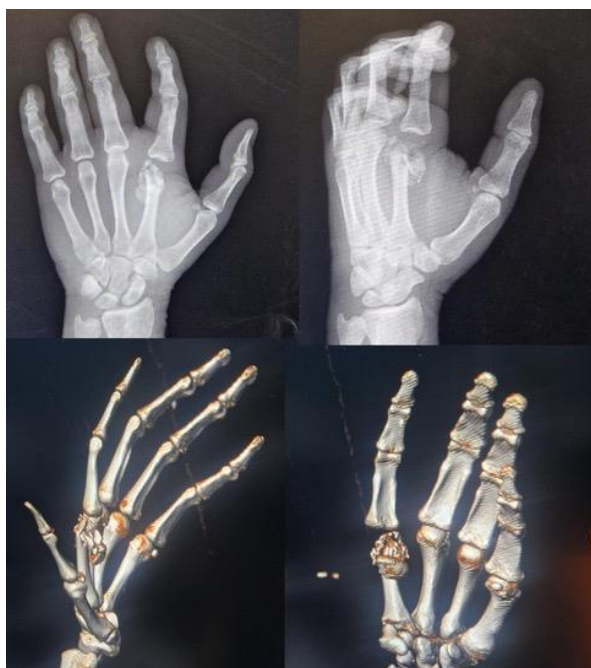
Pre-operative X-rays and CT scan.
